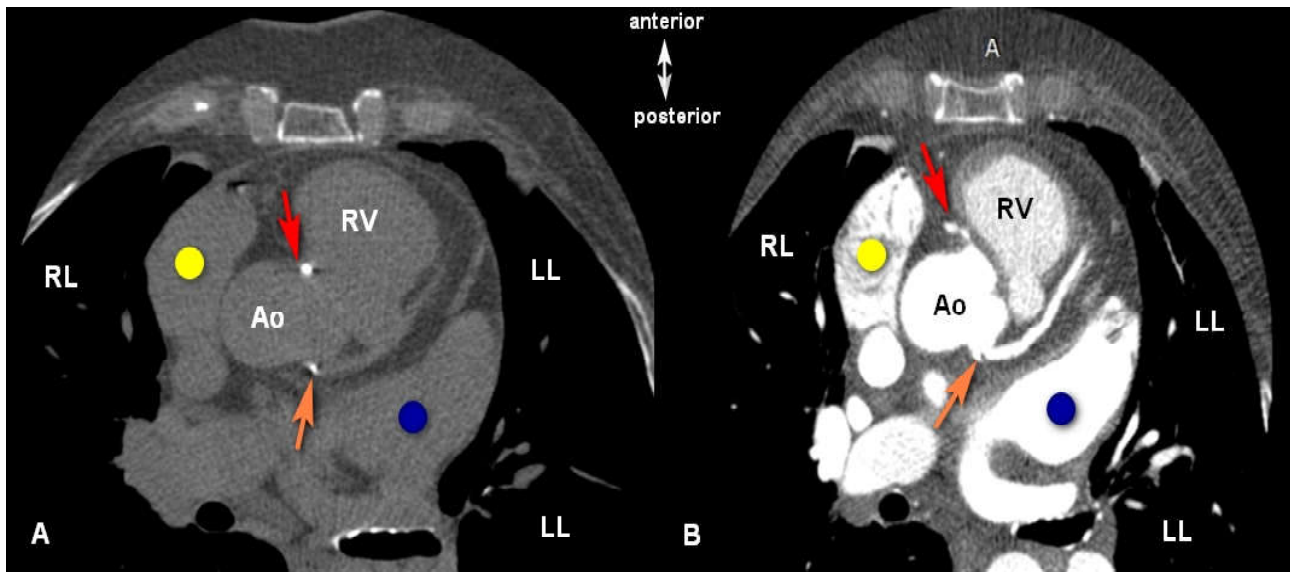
Visualization of the components of the aortic bulb and coronary arteries in structural lesions of the coronary arteries. Image A, without and B, with the introduction of a contrast agent. Ascending aorta (Ao), right ventricle (RV), auricula atrii (yellow circle), left atrium (blue circle), right lung (RL), left lung (LL). A - calcium deposits in the projection of the right coronary artery (red arrow) and the left coronary artery (orange arrow). High calcium density is well visualized on examination without contrast. B - contrasting right coronary artery (red arrow) and left coronary artery (orange arrow). Chest computed tomography, axial section.
